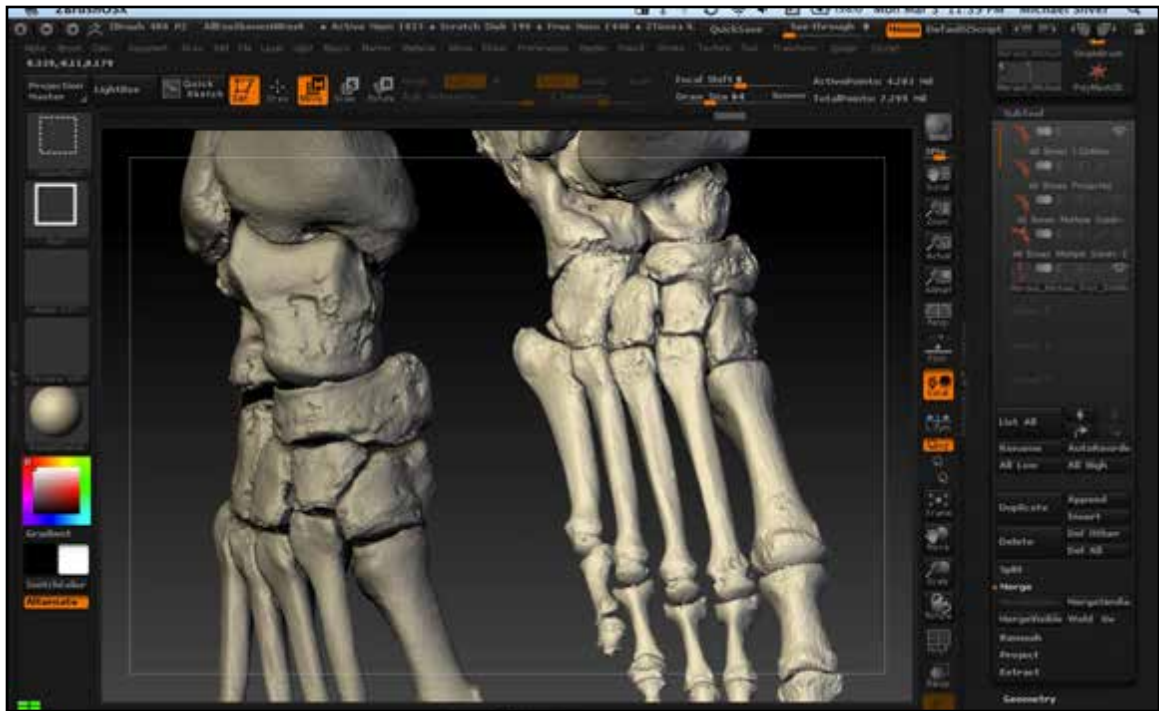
CT based mesh (left) and laser scan data mesh (right).
